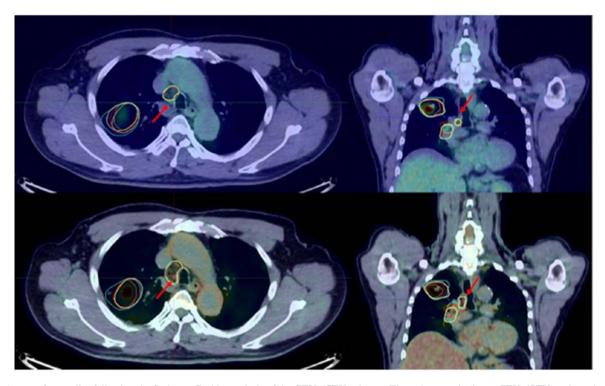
A case of an outlier following the Smirnov-Grubbs analysis of the GTVn/CTVn change. The red arrows indicate: GTVn/CTVn enlarged area based on the difference between cPET/CT and dPET/CT images. GTV, gross tumor volume; CTV, clinical target volume; cPET/CT, conventional positron emission tomography/computed tomography; dPET/CT, digital positron emission tomography/computed tomography.
